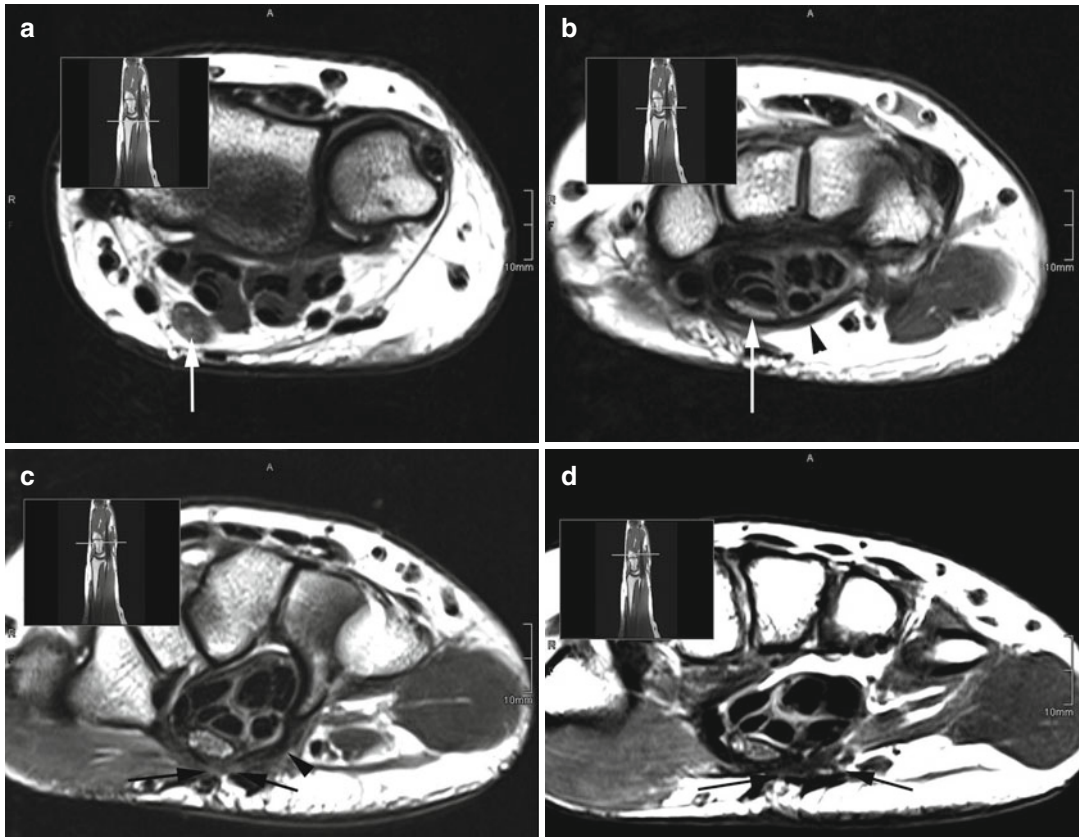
Recurrent carpal tunnel syndrome (CTS) after insufficient dissection of the transverse carpal ligament. Axial T2-weighted images: (a) median nerve (arrow) at the level of the wrist joint before entering the carpal tunnel; the nerve is massively enlarged with increased signal intensity on T2 (higher than the signal of the adjacent musculature) indicating edematous changes of the nerve. (b) Marked flattening of the median nerve (arrow) at the entrance into the carpal tunnel due to the narrowed space between the flexor tendons and the portion of the transverse ligament left intact (arrowhead). (c) Dissected
